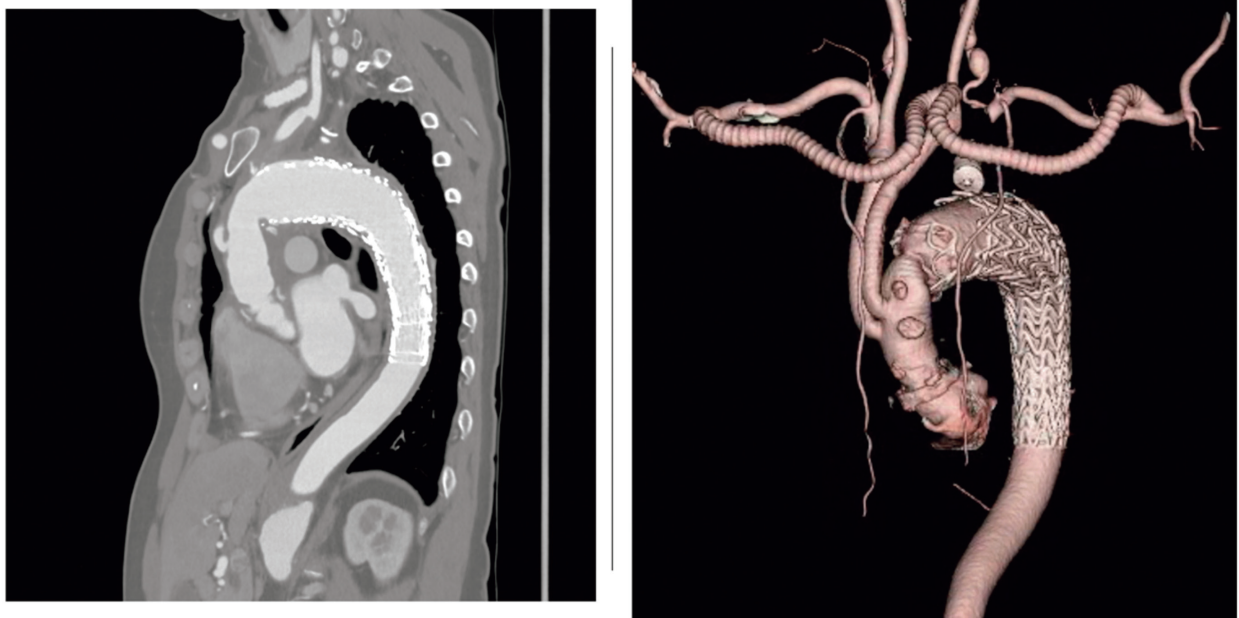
Contrast-enhanced computed tomography one month after total arch replacement showed the exclusion of aneurysm.
